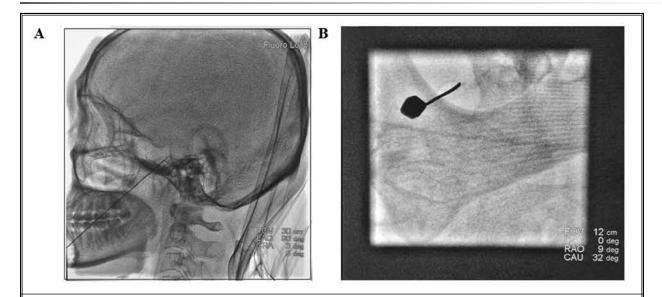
Digital subtraction angiography (DSA)-guided puncture of the Gasserian ganglion. (A) lateral radiographs (Fig. 1A) and (B)oblique radiographs.
